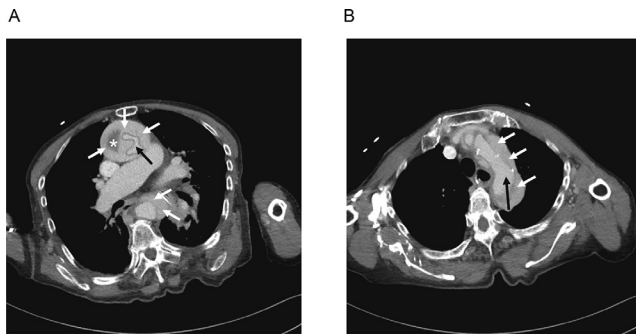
Contrast-enhanced CT of an 80-year-old woman with type A communicating aortic dissection who was transferred to a facility for cardiovascular surgery after undergoing emergent coronary angioplasty. The dissection extended from the aortic root (A) to the aortic arch (B) and to the thoracic descending aorta (A). Black and white arrows indicate true and false lumens, respectively. Thrombus formation was in part observed in the false lumen (asterisk).
